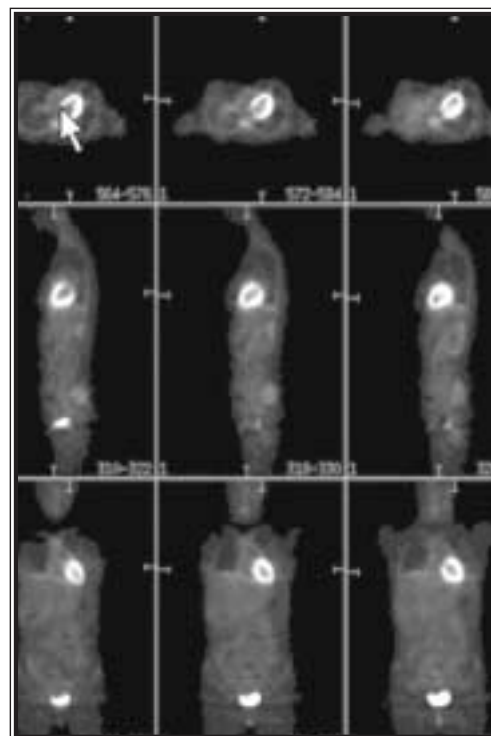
Increased cardiac uptake as a result of elevated glucose causes increased insulin output from the pancreas. Patient drank a large quantity of fruit juice prior to the FDG injection.
